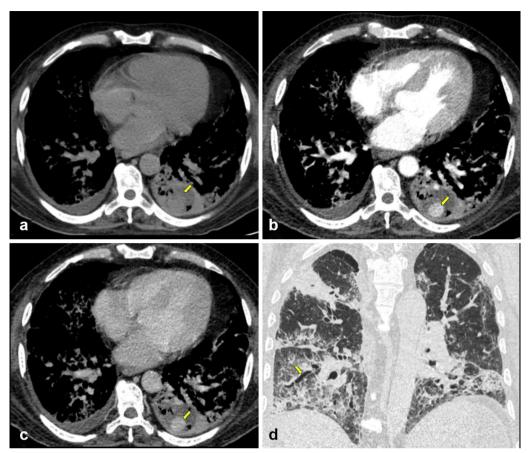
(Multiphase CT): NCCT a shows a cavitatory lesion in the left lower lobe with internal hyperdense contents and air foci (arrow). Arterial (b) and venous (c) phase post-contrast images show pseudoaneurysm (arrows) associated with the cavitatory lesion. Lung window (d) showing post-COVID-19 changes in the form of septal thickening, ground glass opacities, and traction bronchiectasis (arrow)
